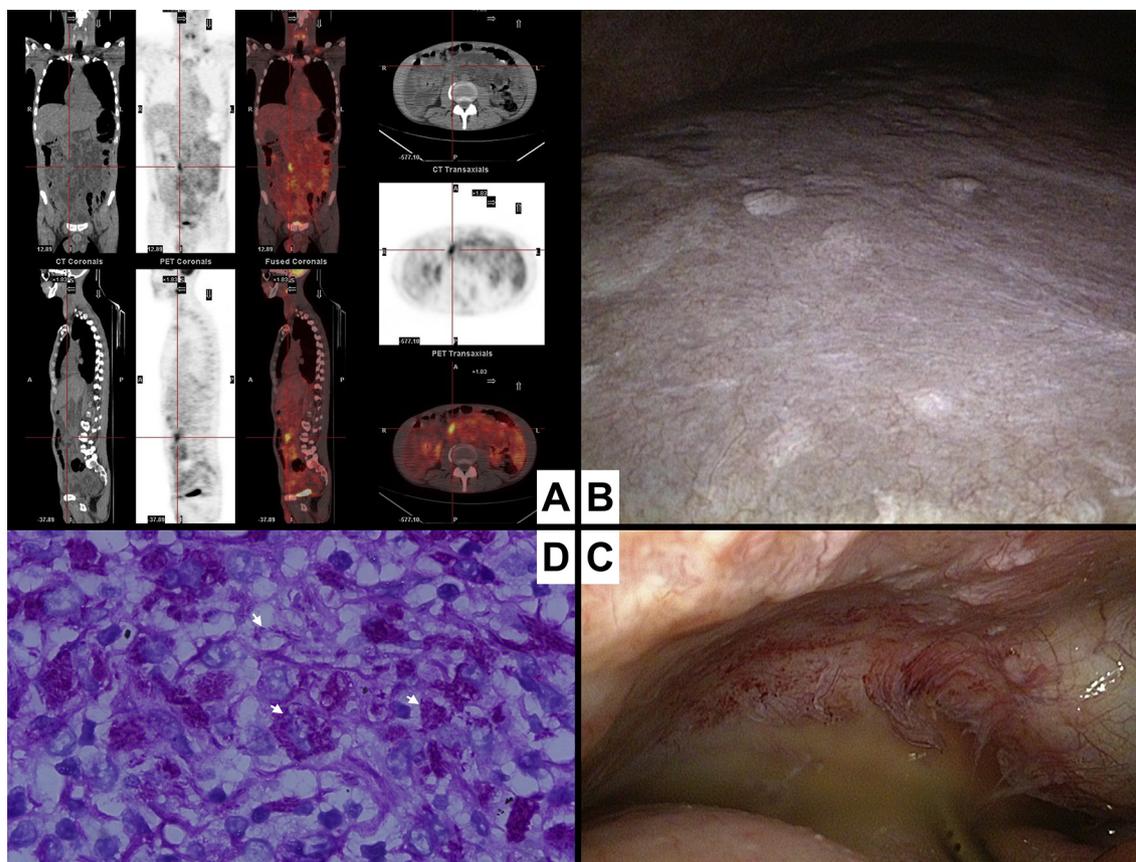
Image and pathological finding of the patient: A) PET scan revealed multiple FDG-avid mesenteric lymphadenopathies; B) Miliary whitish plaques were found on the peritoneum during laparoscopy; C) Inflamed peritoneum and turbid ascites were also found during laparoscopy; D) Numerous PAS-positive short bacilli (arrows) were found in the excised lymph node.
